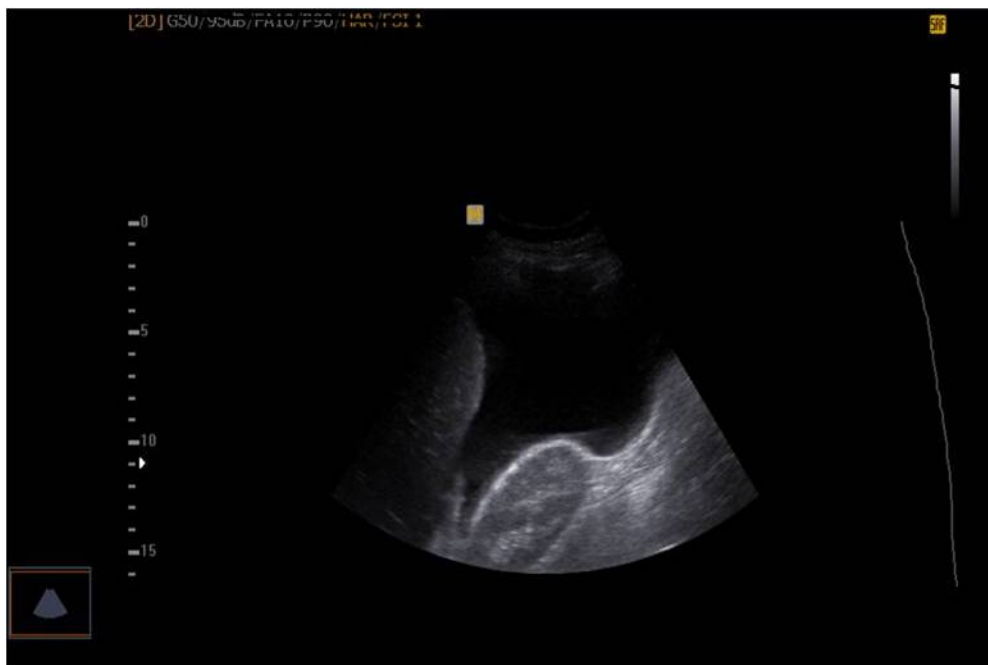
Abdominal ultrasonography revealed marked intraperitoneal collection.
